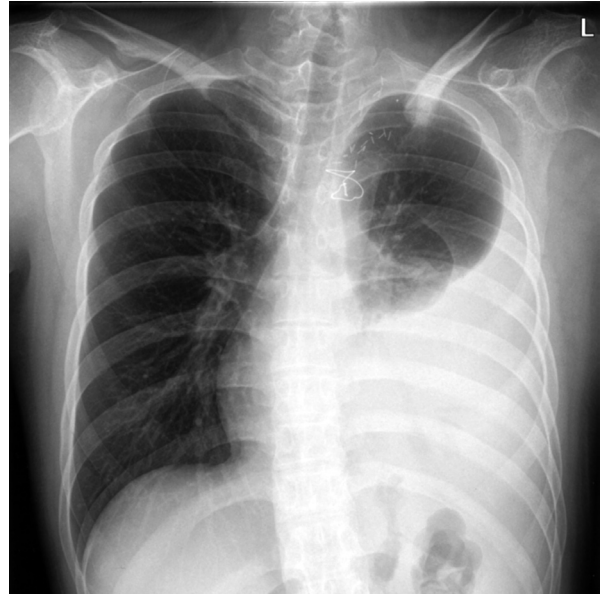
Three months later, the chest X-ray revealed a large amount of pleural effusion. After debulking surgery and photodynamic therapy for 3 months, the pleural effusion decreased.
